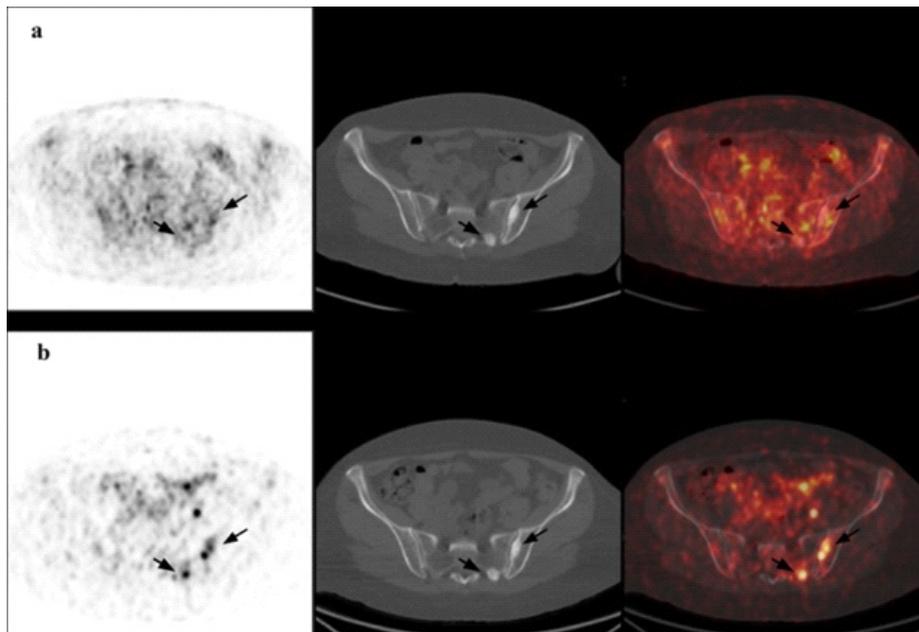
a-b. A 57-year-old female patient with medullary thyroid carcinoma had elevated serum calcitonin and carcinoembryonic antigen levels (3662.4ng/L and 5.6ng/mL, respectively). Axial ^{18}F -FDG PET and fused PET/CT images (a) fail to show metastases, whereas axial ^{68}Ga -DOTATATE PET and fused PET/CT (b) images showed increased uptake on left iliac bone and sacrum, which were in accordance with bone metastases (arrows).
